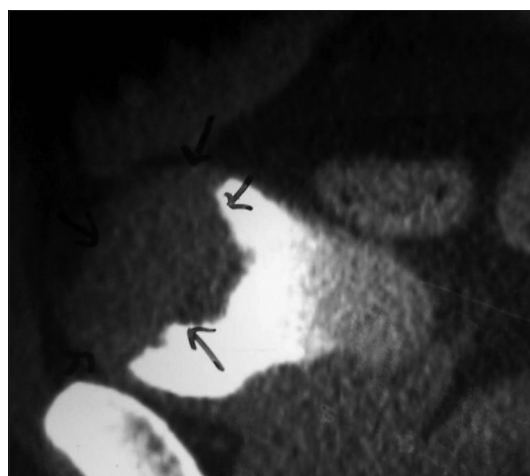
Computed tomography scan showing dome and anterior bladder wall malignancy
